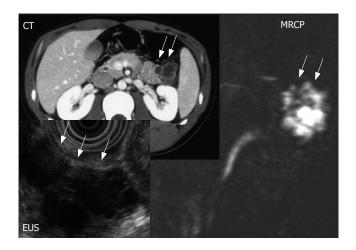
Case No. 3. A 25 yr old male. The imaging procedures such as abdominal CT scan, EUS and MRCP suggested a branch type of IPMN.
